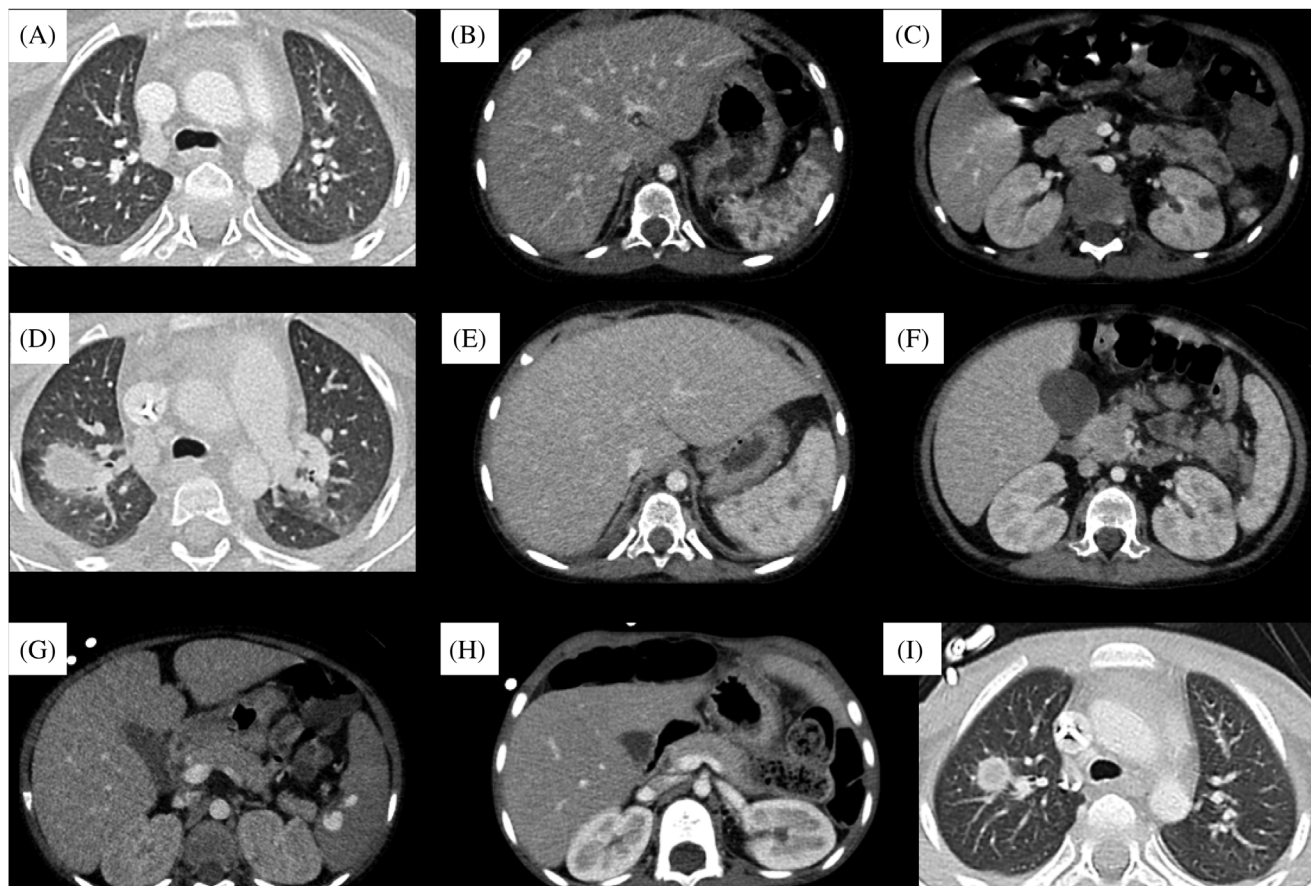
Computed tomography (CT) scan findings. (A–C) Contrast-enhanced CT scans on day –29 revealed disseminated lesions in the lung, spleen, and kidney. (D) Contrast-enhanced CT scans on day 14 demonstrated a new well-circumscribed lesion in the right lung. (E, F) Contrast CT on day 15 showed the improvement of disseminated lesions in the liver and spleen. (G) Contrast-enhanced CT scans on day 38 revealed multiple pseudoaneurysms in the spleen. (H, I) Contrast-enhanced CT scan on day 211 showed the persistence of nodular lesions in the lungs, while the lesions in the kidneys disappeared.
